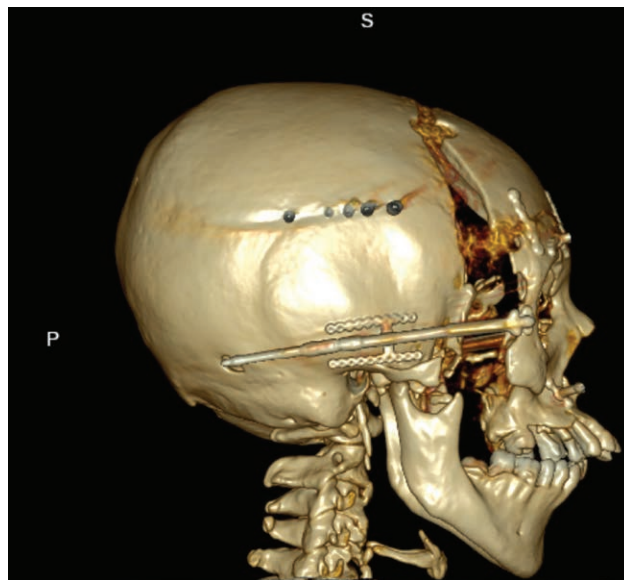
Postoperative right lateral 3D CT image demonstrating distraction of midface with improvement of zygomatic arch position, occlusion and placement of distractors.
